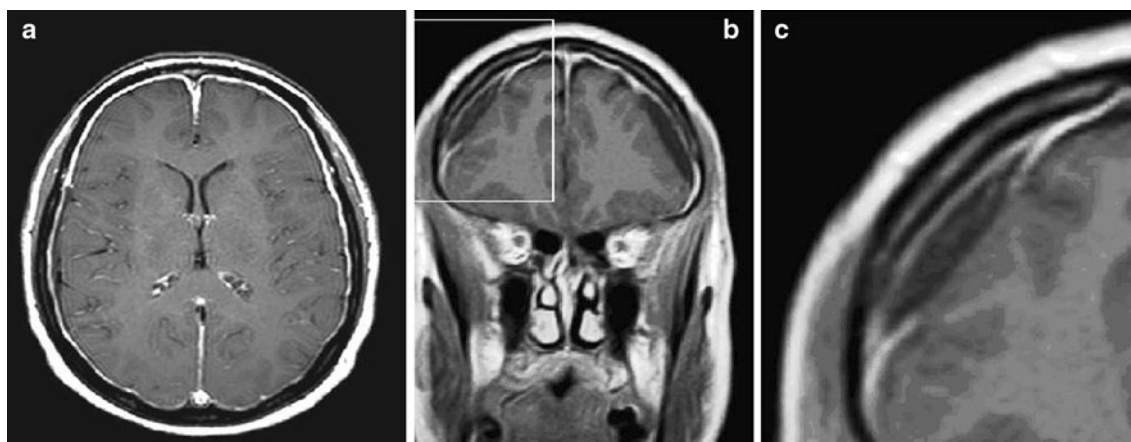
a–c Axial T1-weighted image (*left*) after intravenous contrast medium demonstrate intense, linear and diffuse pachymeningeal enhancement along the cerebral convexities and the falx cerebri. Coronal T1-weighted image (*middle*) after contrast medium
